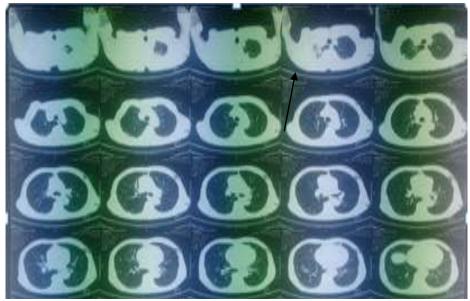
Axial contrast-enhanced CT scan shows the 6 cm right apical mass.
